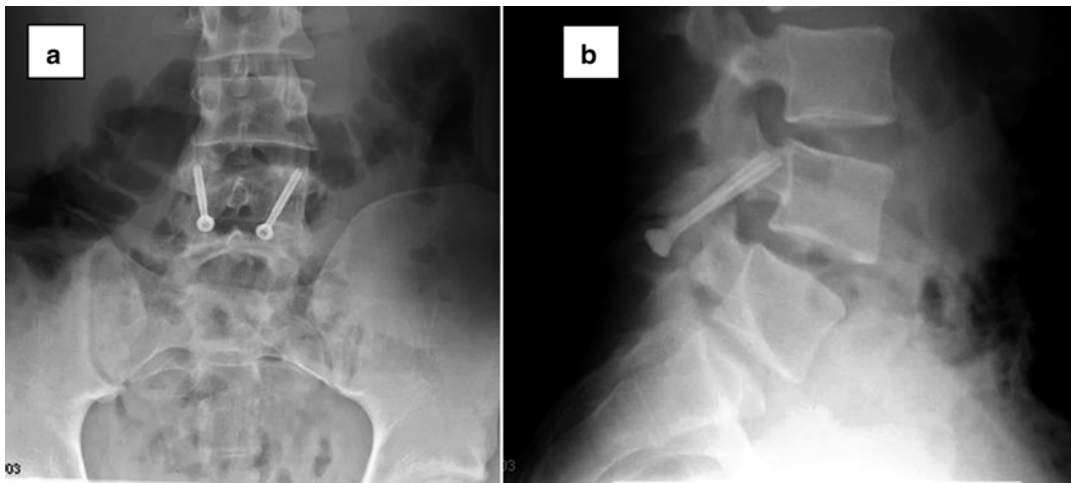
(a, b) AP and lateral radiographs after direct laminar/pars compression screw fixation
